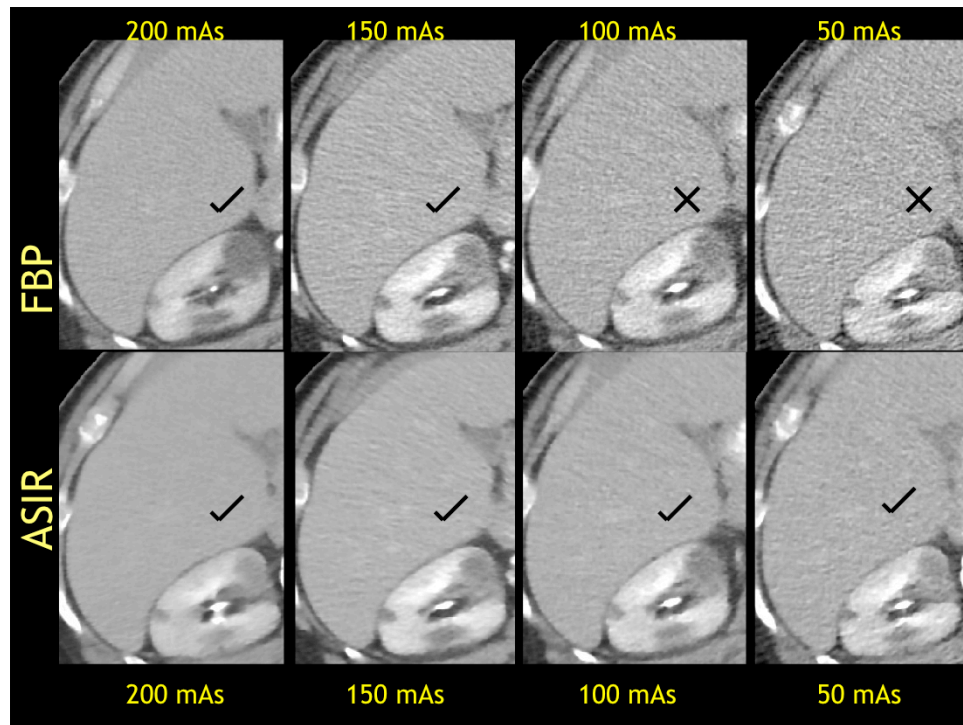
Transverse abdominal CT images acquired at four tube current levels (200, 150, 100 and 50 mAs) and resultant radiation dose levels (16.4, 12.6, 8.4 and 4.2 mGy) were reconstructed with FBP and iterative reconstruction technique (Adaptive Statistical Iterative Reconstruction, ASIR, GE Healthcare). ASIR enabled images shows lower image noise at each dose level and better visibility of low attenuating renal lesions.
